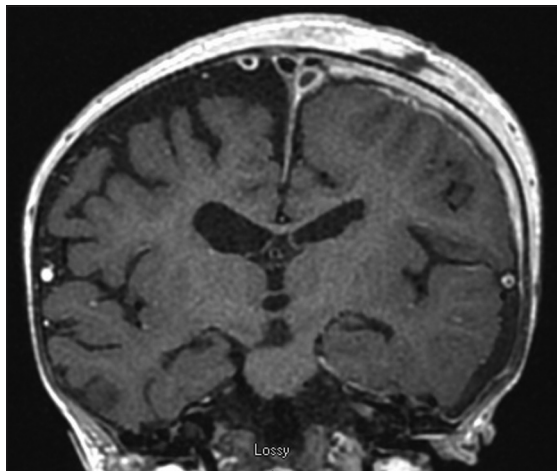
Postoperative MRI with interval evacuation of the infected fluid collection and resolved mass effect.
